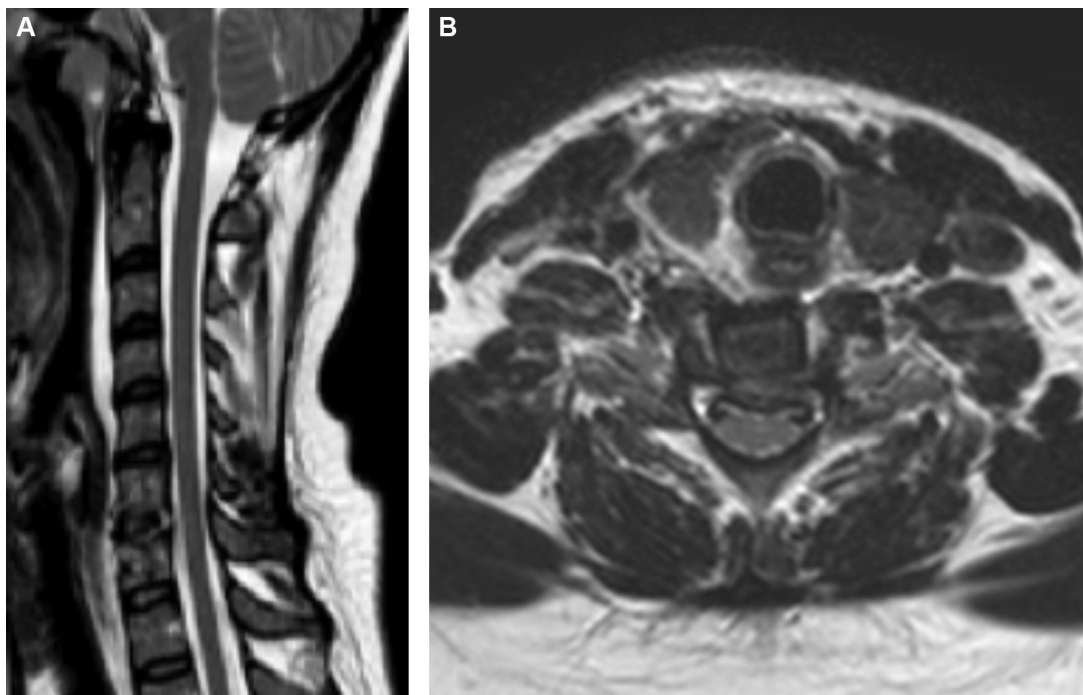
MRI of the spinal cord, T2-weighted sequence, on the day after surgery: C6–C7 cage and absence of spinal cord abnormalities on the sagittal (A) and axial (B) images.
